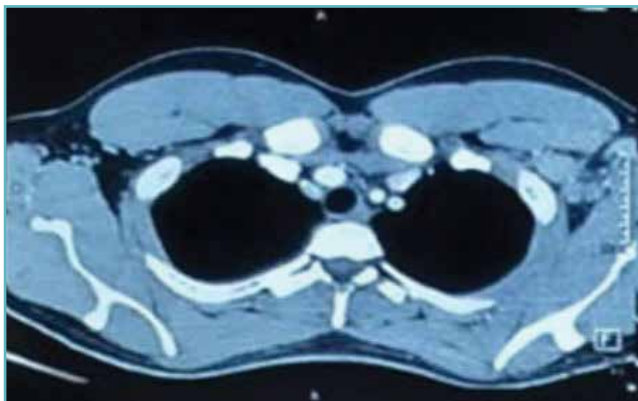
Contrast-enhanced computed tomography (CECT) chest (performed externally) showed at least three enlarged homogenous axillary lymph nodes, largest measuring 3.8 X 2.7 cm.
